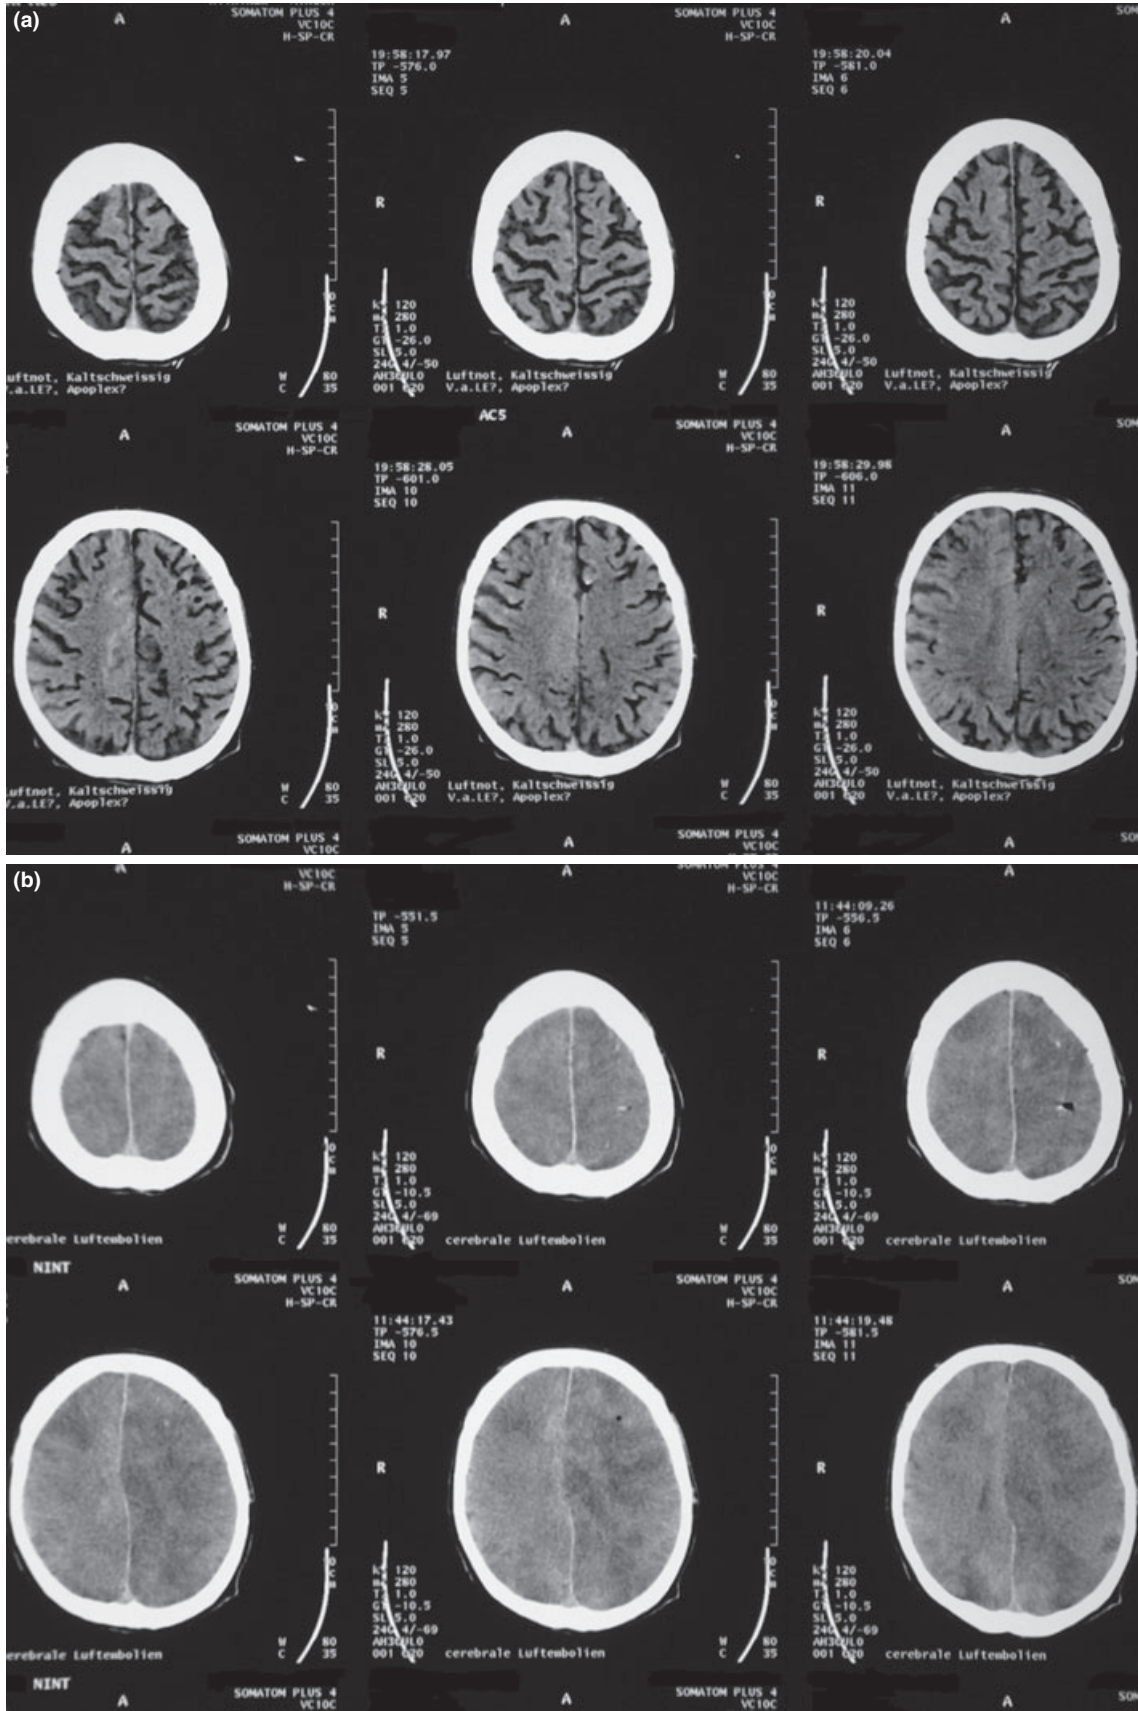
(a) Cerebral CT performed shortly after the beginning of the symptoms. Multiple air bubbles distending the superficial veins (in black) in the depth of the gyri and the bridging veins. (b) Two days later only few residual air bubbles could be detected (in black, visible in the image at the right side of the superior line and in the central one of the inferior line). The investigation showed severe edema and areas of necrosis corresponding to venous infarctions.
